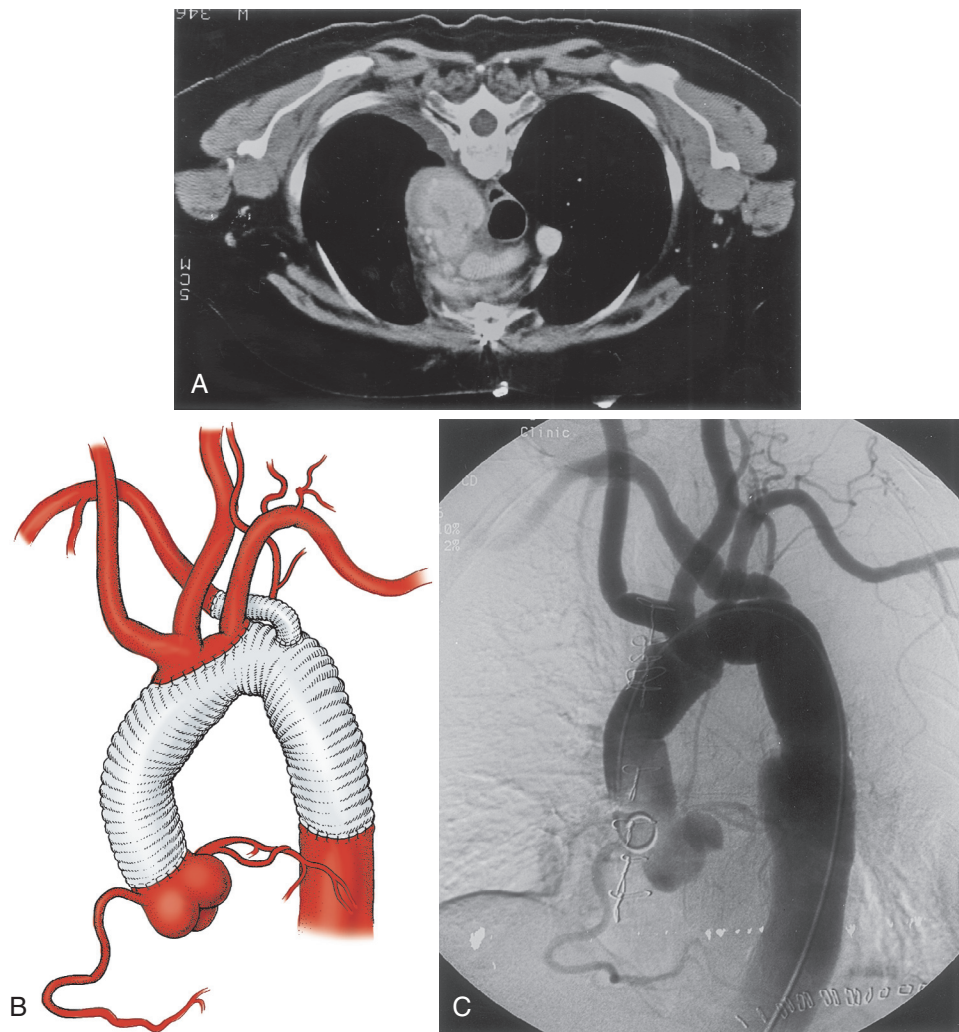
■ A, Computed tomography scan of an aortic arch aneurysm associated with an aberrant right subclavian artery that was treated by a modified elephant trunk technique. B, The first stage of the elephant trunk procedure was done with an anastomosis between the left subclavian artery and the aberrant right subclavian artery, and the second stage was performed with an interposition graft to the right subclavian artery. C, Angiogram of the completed repair. Note the tube graft to the right subclavian artery arising from the more distal part of the aortic arch.
